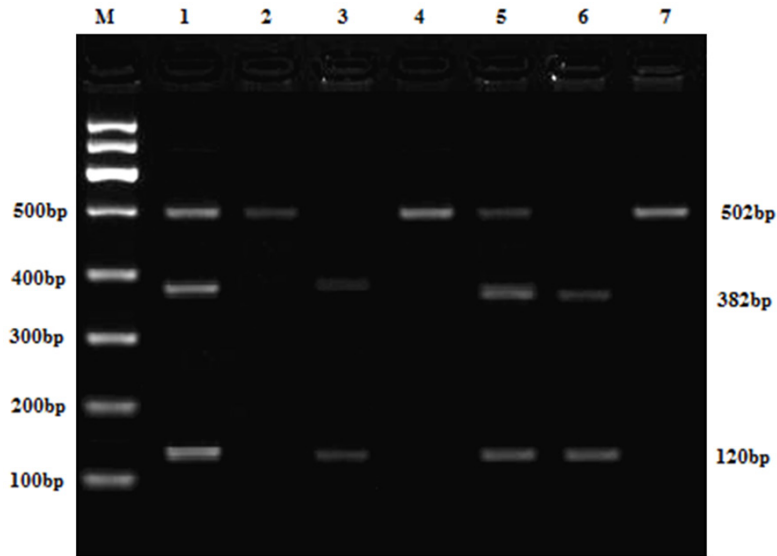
Agarose gel electrophoresis images for *ABCB1* C1236T. 3, 5 and 6 lanes: CC genotype; 1 and 5 lanes: CT genotype; 2 and 7 lanes: TT genotype.
